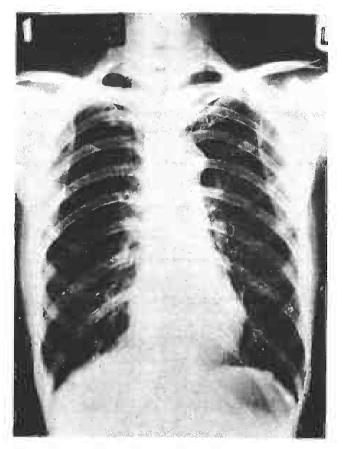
Chest radiograph of patient with complete resolution of the right pleural effusion on the 14th post-operative day.
